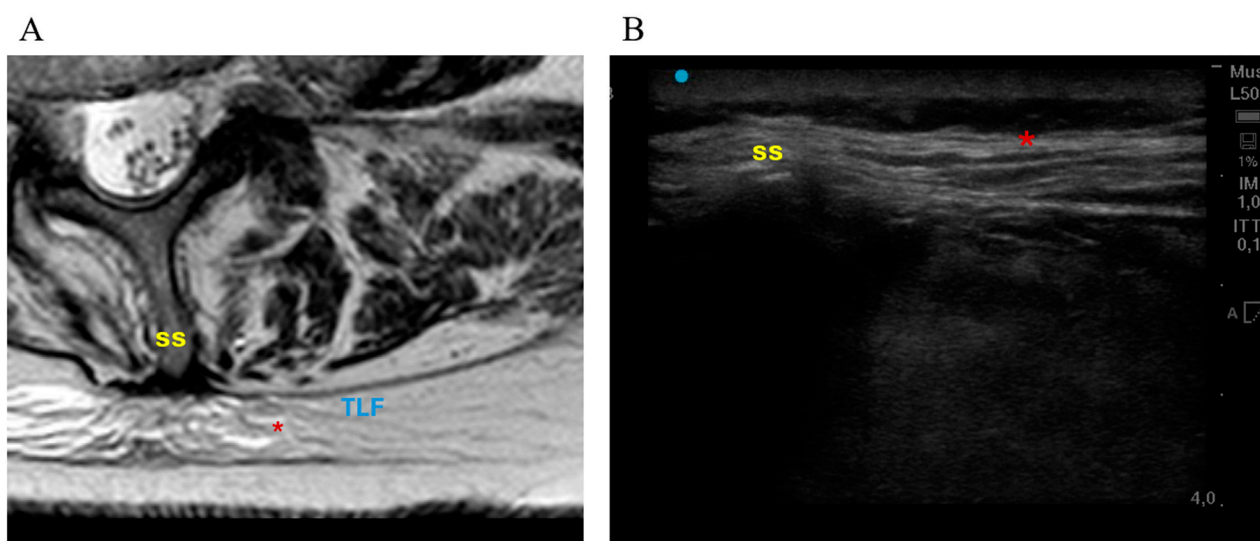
MRI (A) and US (B) at the L3 level of a female subject. SS = spinous process. On MRI, fibrosis of the deep adipose tissue is visible (*), which may appear as part of the thoracolumbar fascia (TLF) on the corresponding US image, creating an artifact of increased thickness.
